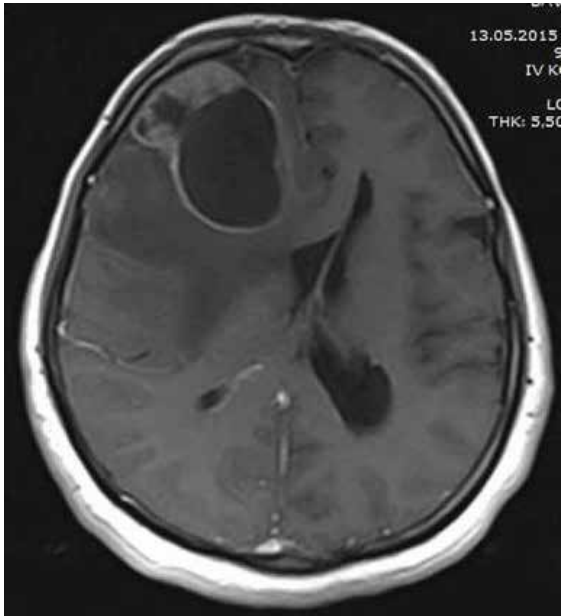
T1- weighted axial MRI scan of the brain (after i.v. gadolinium administration). T1- weighted axial MRI showed a lesion in the right frontal lobe.
